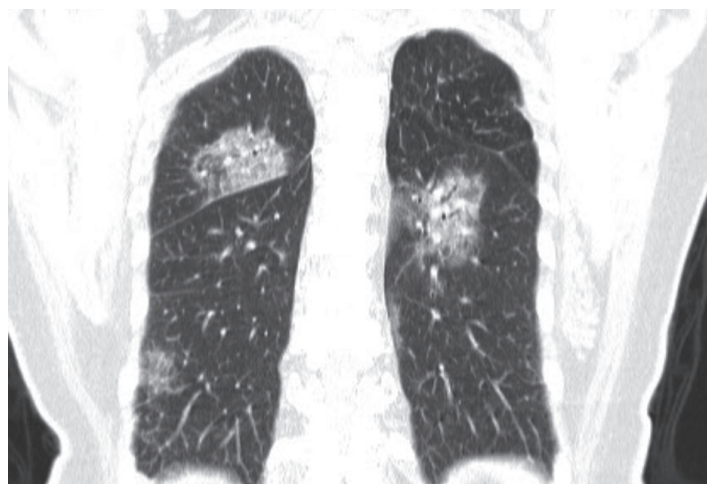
Belizean patient confirmed with COVID-19. Coronal reformatted CT image. Bilateral patchy areas of ground glass opacity (GGO) with bronchovascular thickening within the lesions.
